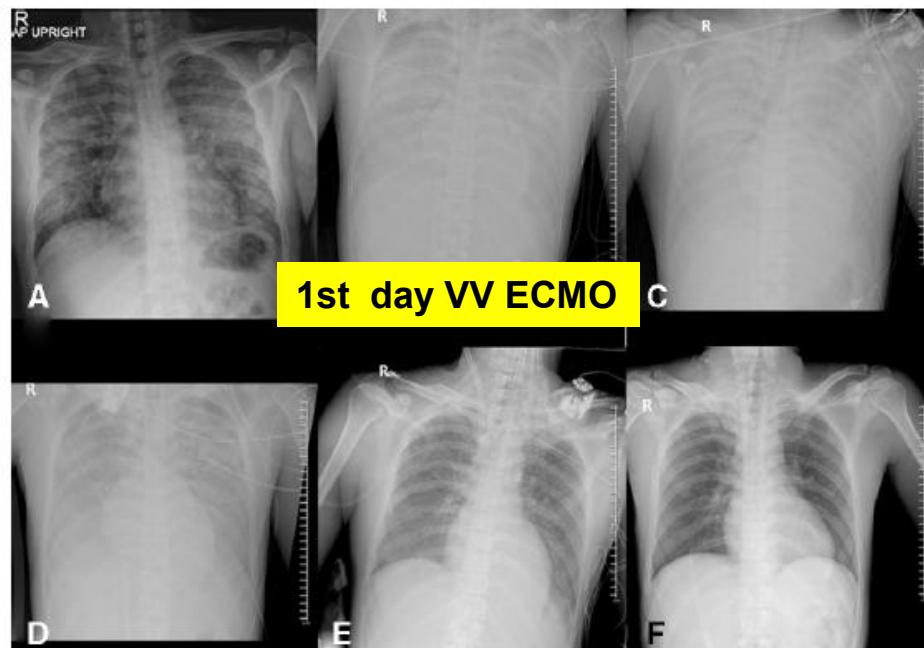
(A) Chest X-ray of the patient on day 1 before VV-ECMO. (B) Chest X-ray of the patient on day 1 after VV-ECMO. (C) Chest X-ray of the patient on day 2. (D) Chest X-ray of the patient on day 3. (E) Chest X-ray of the patient on day 5. (F) Chest X-ray of the patient on day 10. VV-ECMO, venovenous extracorporeal membrane oxygenation.
